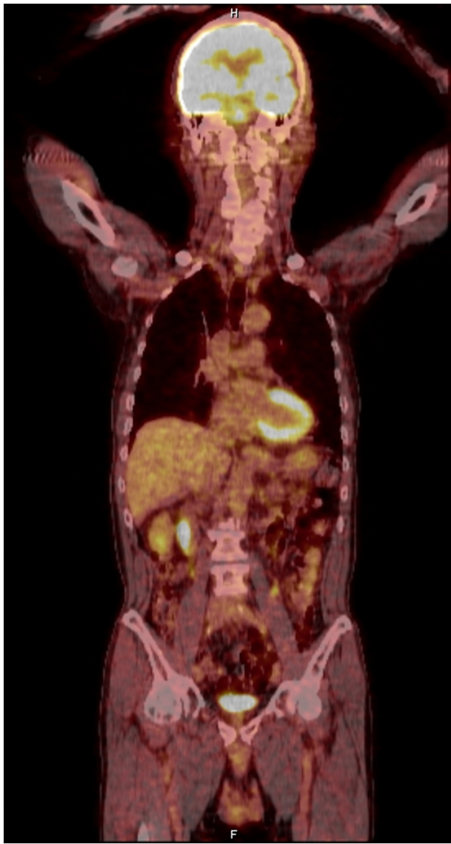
Postoperative PET-CT image showing no evidence of tumor
